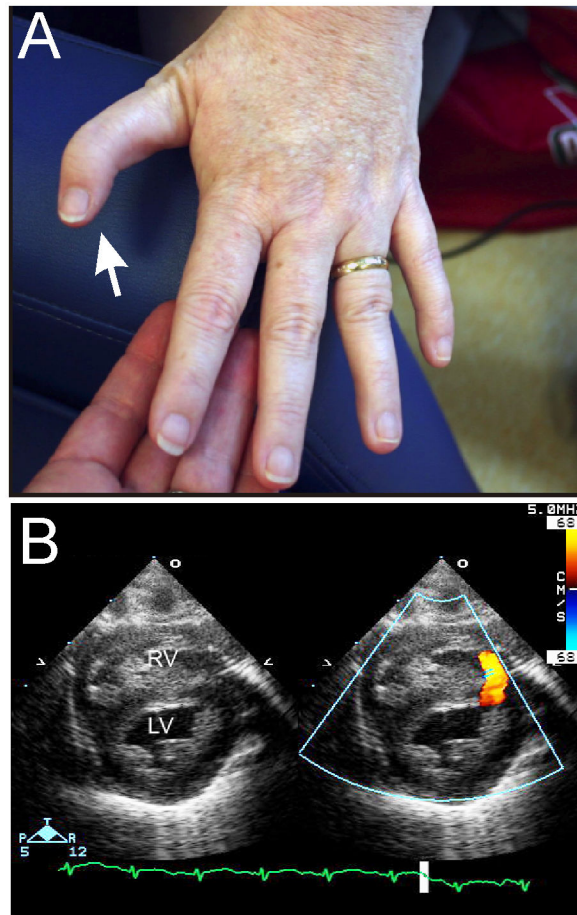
Phenotypic features of DBA. (A) Abnormal thumb in an adult with an *RPL11* mutation. (B) Muscular ventricular septal defect. Color indicates blood flow across the defect. Abbreviations: LV, left ventricle; RV, right ventricle. Echocardiogram courtesy of Patrick Jay, M.D., Ph.D.
